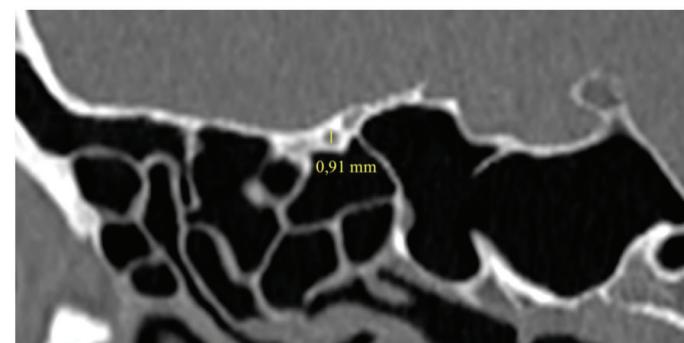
Posterior ethmoidal artery diameter on a CT scan of patient Pham Van T. Source: Dang Vuong Kiet, 2023.
